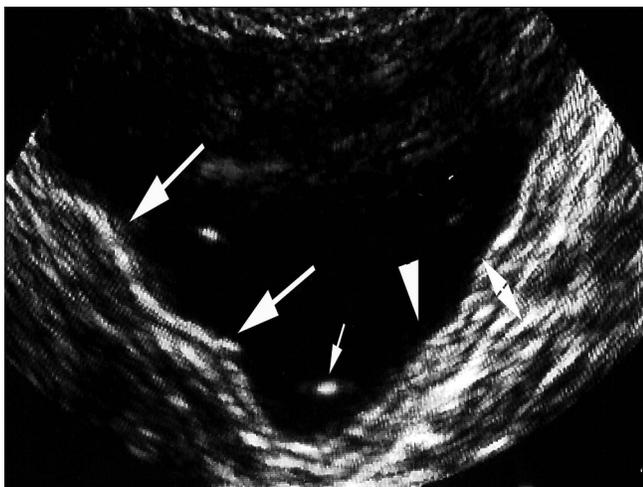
Sample sonograms of the duodenal wall in patients with acute giardiasis
